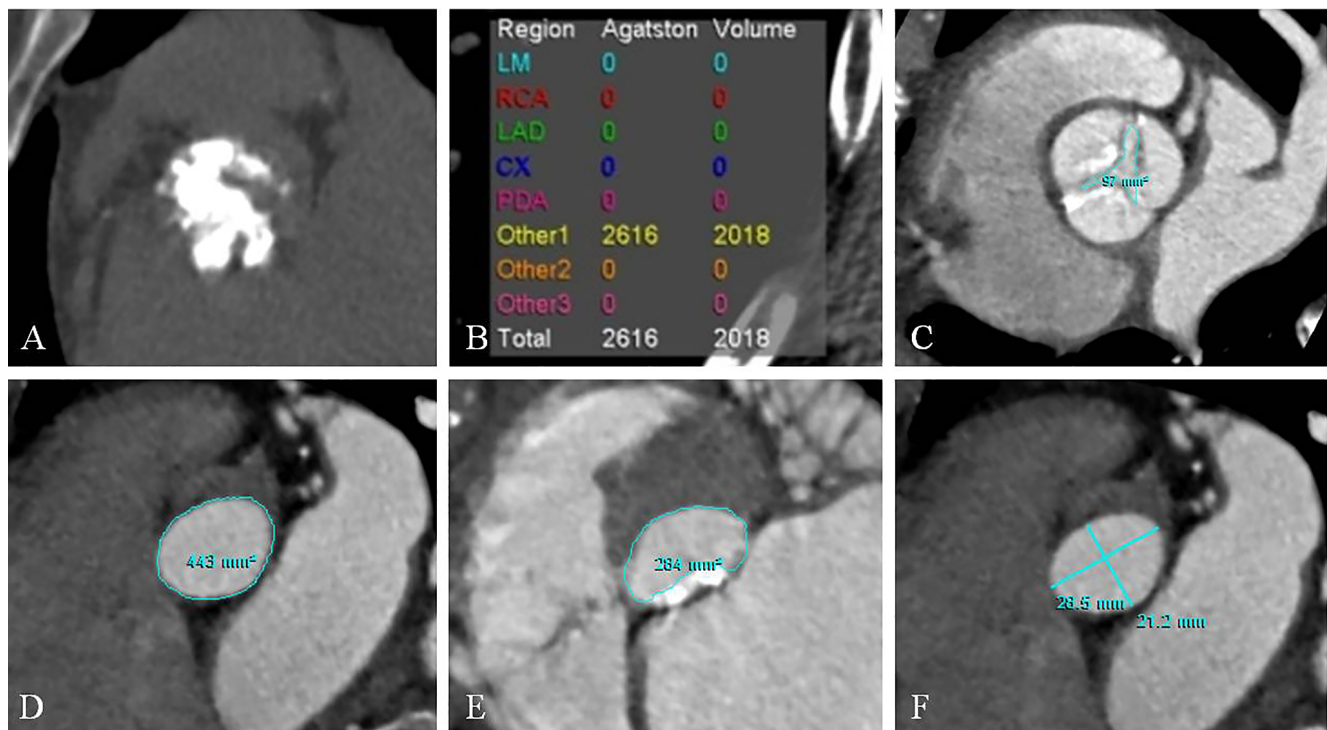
Cardiac computed tomography image analysis before transcatheter aortic valve replacement includes (Panel A) degree of aortic valve calcification and Agatston aortic valve score, (Panel B) aortic valve area (AVA) measurement, (Panel C) left ventricular out-flow tract (LVOT) area measurement without calcification, (Panel D) LVOT area measurement with calcification, and (Panel E) minimum (D_{\min}) and maximum (D_{\max}) diameters of LVOT.
